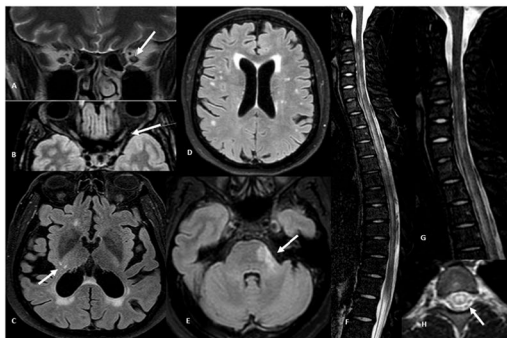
(A) Brain coronal T2 weighted image showing hyperintensity of the left optic nerve (ON). (B) Brain axial T2-FLAIR demonstrating atrophy of the anterior segment of the left ON. (C-E) Brain axial T2-FLAIR hyperintensities involving the right thalamus and internal capsule (C), the bilateral subcortical and periventricular white matter (D), as well as the protuberance and left middle cerebellar peduncle (E), in three patients. (F and G) Spine sagittal STIR showing longitudinal extensive patchy lesion spanning from cervical to thoracic cord. (H) Spine axial T2 with hyperintense "H" sign outlining the central gray matter of the spinal cord.
